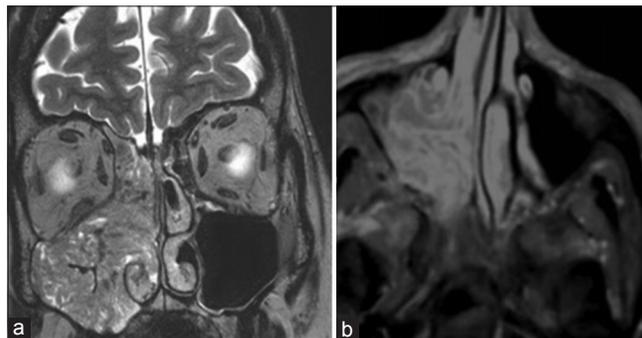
(a and b) Magnetic resonance imaging scan: Soft tissue mass in the right middle meatus extending to the right maxillary sinus shows heterogeneous enhancement on T1- and T2-weighted images
